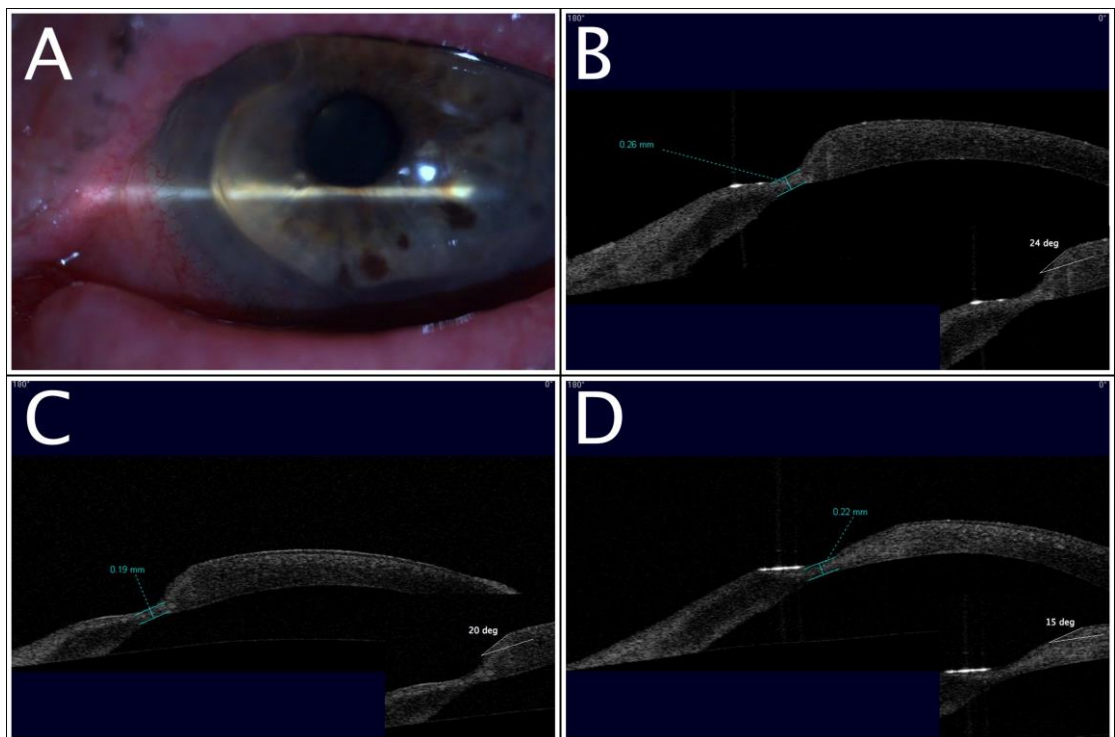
Case 1. Serial AS-OCT scans through the peripheral ulcerative keratitis in association with rheumatoid arthritis. A. Photo at presentation shows peripheral corneal thinning with a ‘contact lens cornea’ appearance. B. At the acute presentation, the gradient of the ulcer walls was steep, the steepest measuring 24° . The cornea at the ulcer base was thin and minimum corneal thickness (CT) measured $260\text{ }\mu\text{m}$; the adjacent cornea appeared thickened, most likely due to oedema. C. Three days later, following successful
